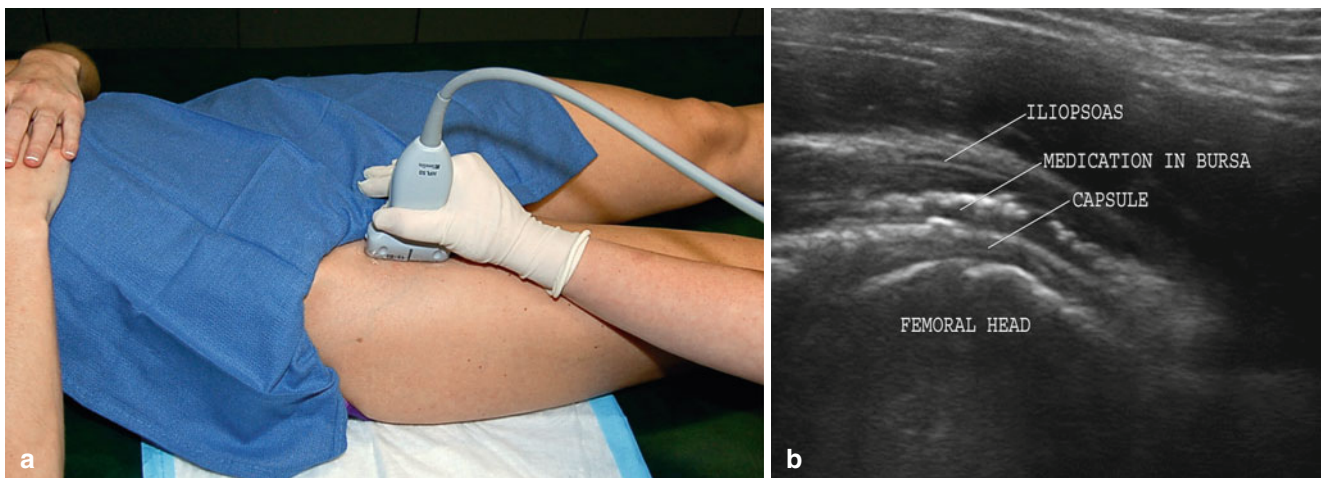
(a) After the injection, placing the transducer over the iliopsoas in long axis will allow visualization of the medication in the bursa between the joint capsule and the iliopsoas musculature. (b) Long axis ultrasound image after injection of medication into the bursa. The image
